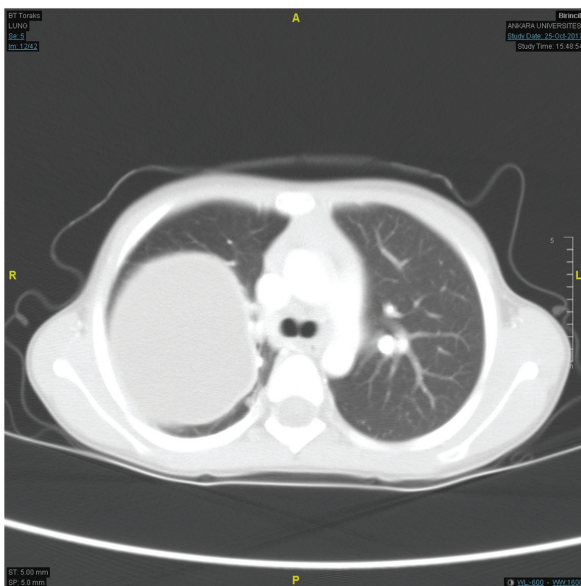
CT scan of cyst hydatid
